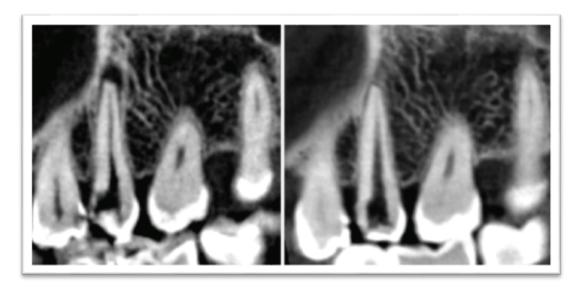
Pre-operative and Post-operative (1 year follow up) CBCT showing healing of periapical lesion related to upper left second premolar in sagittal plane.
